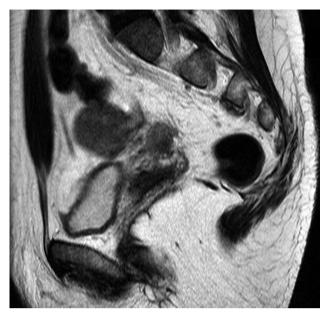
Sagittal T2-weighted MRI showing a low-signal-intensity area correlated with endometriosis parametrial involvement.
